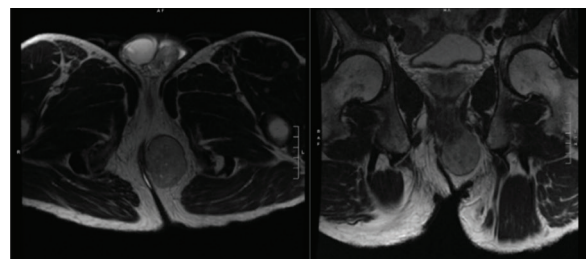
Representative cuts of the patient's MRI showing the large ischiorectal tumor involving the external anal sphincter and levator ani
